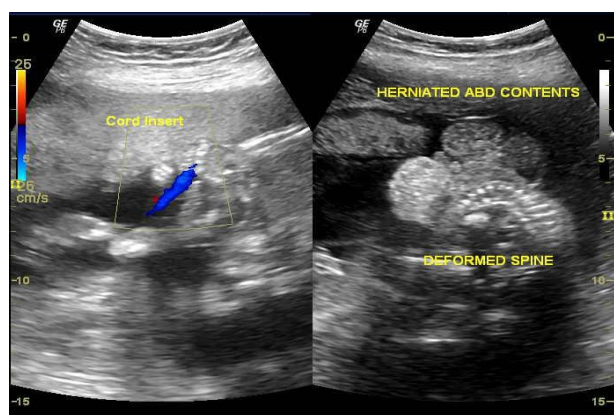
Ultrasound image showing deformed spine and large abdominal wall defect with herniated abdominal content
